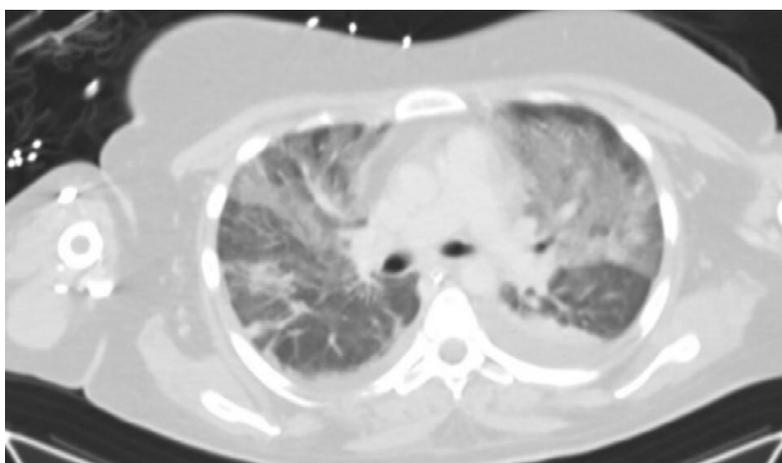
CT chest showing left consolidation.
